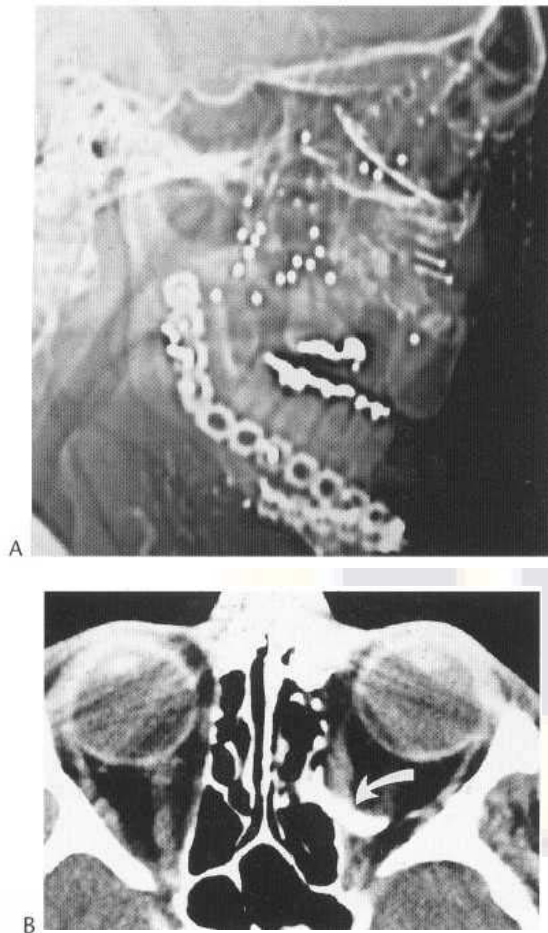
Displaced metallic orbital floor prosthesis. Lateral scout radiograph (A) demonstrates operative fixation of previous mandible fracture and orbitonasal injuries. Punctate densities represent projectiles from recent shotgun blast. Axial CT image (B) demonstrates upward displacement of metallic orbital floor prosthesis (arrow).
